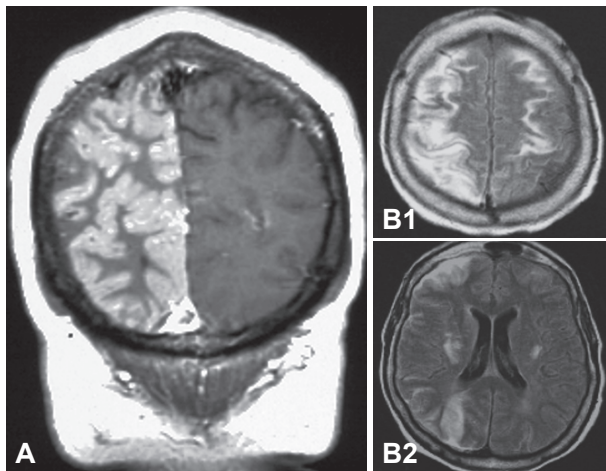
Fluid attenuated inversion recovery sequences of MRI scans. MRI show increased signal involving unilateral (A) or bilateral (but predominantly unilateral) (B1 and B2) gyri and their underlying white matter in two patients who developed severe migraine.
